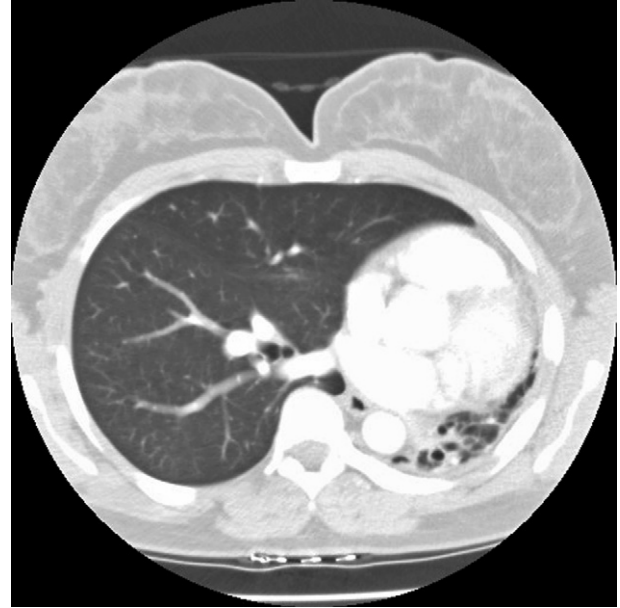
CT thorax showing underdeveloped lung parenchyma on the left and herniation of right lungs towards left lung.
